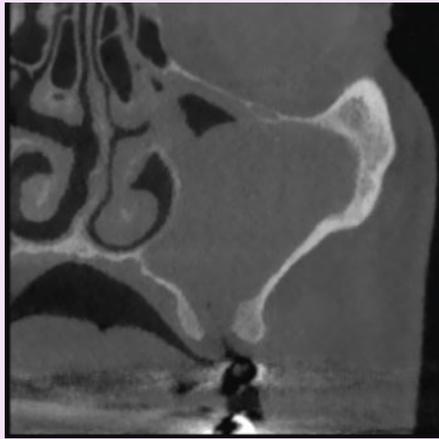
Coronal CBCT slice demonstrating the presence of an oro-antral communication following extraction of 26. The left maxillary sinus is opacified due to inflammatory mucosal thickening, secretions, passage of fluid from the oral cavity, or a combination of these
